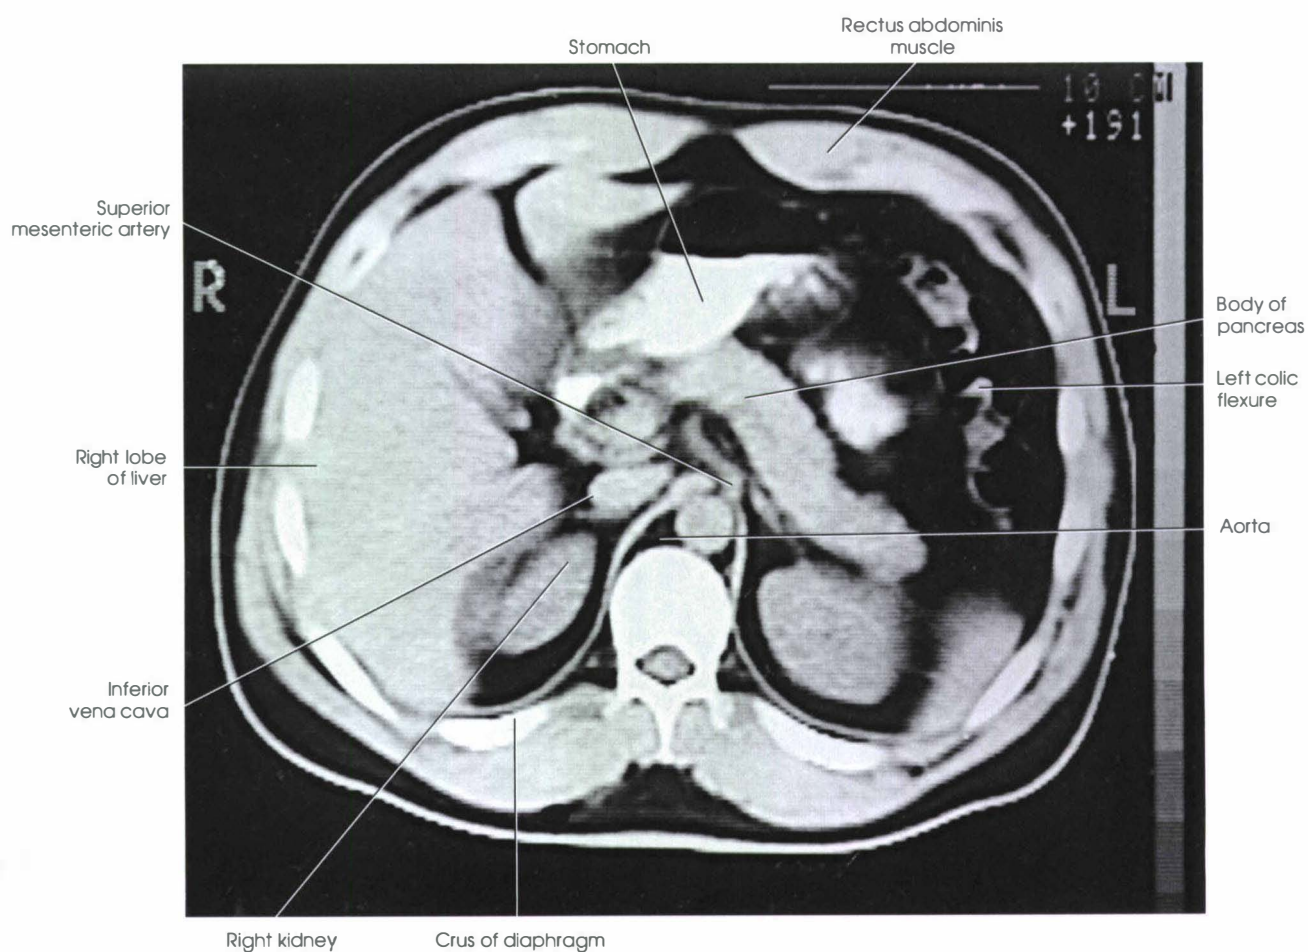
CT image corresponding to Fig. 27-30.
